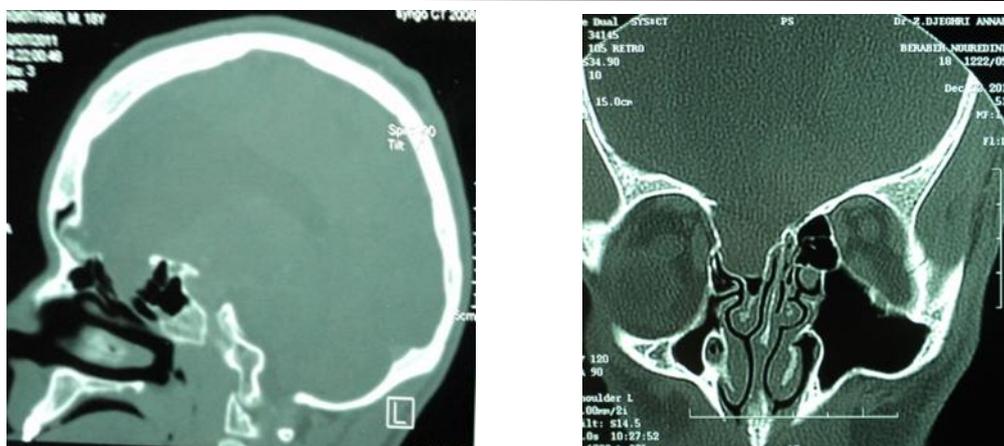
a brain CT scan in sagittal and frontal sections which shows the osteo-dural defect at the level of the anterior skull base with opening of the posterior wall of the frontal sinus.
